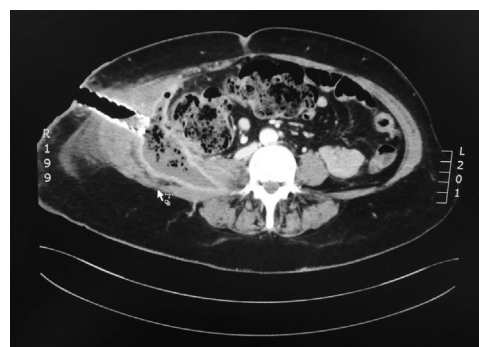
CT scan after 2 sessions of endoscopic necrosectomy with the powered endoscopic debridement system (EndoRotor) through the percutaneous esophageal self-expandable metal stent.
